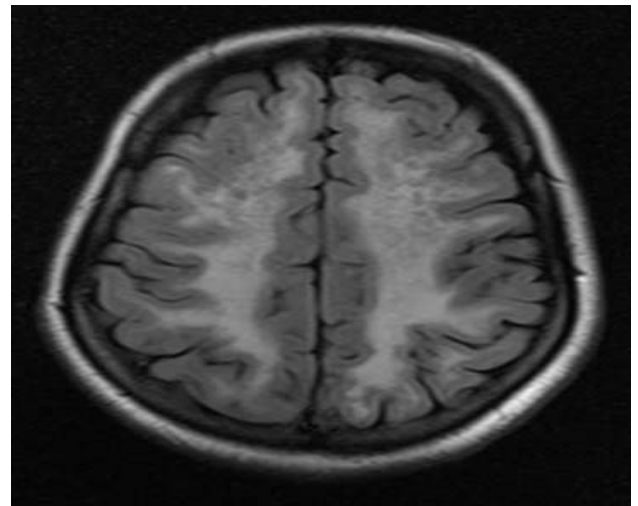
FLAIR sequence of MR Brain in patient with suspecting PML depicting confluent hyperintense signal in subcortical white matter.
